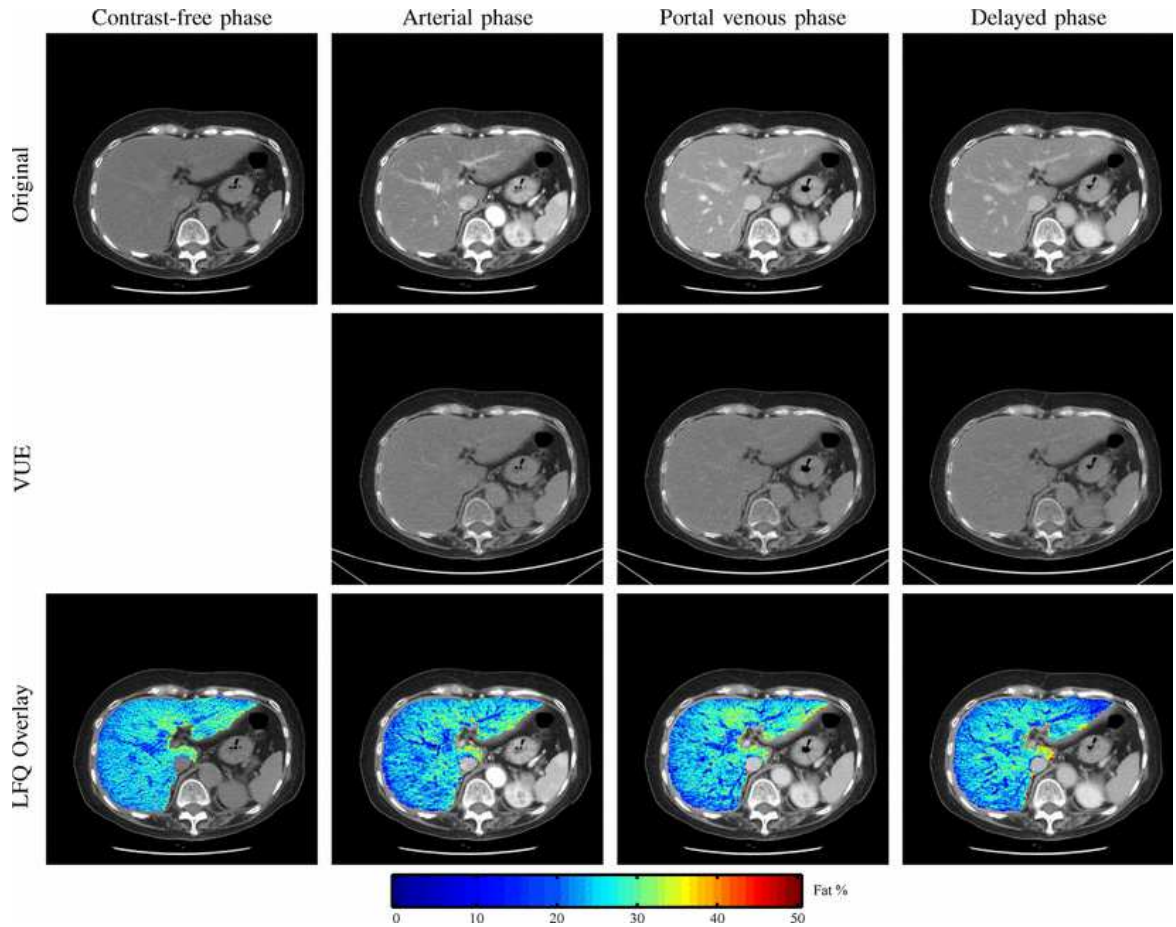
Visualisation of the quantity of fat in the liver, as identified by dual-energy CT. Fat is assigned a rainbow colour scheme, and then overlaid onto slices of an energy volume. “VUE” stands for Virtual UnEnhancement - a technique for removing contrast agents from contrast-enhanced dual-energy CT exams during visualisation. “LFQ” stands for liver fat quantification. Figure from: Mendonca et al. A Flexible Method for Multi-Material Decomposition of Dual-Energy CT Images. IEEE Transactions on Medical Imaging, 2014, 33, 99-116. © 2014 IEEE, used with permission.
